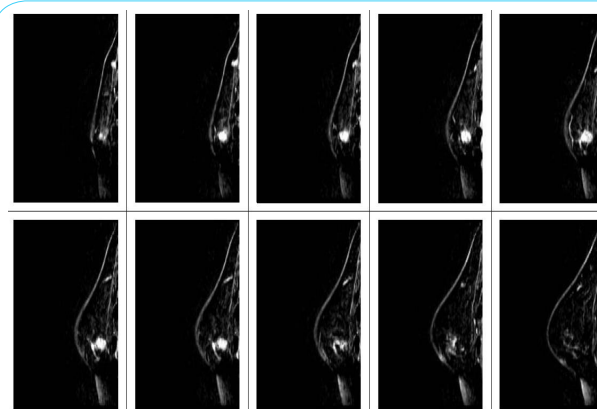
Partial slices of an actual breast MRI case with breast tumors.
